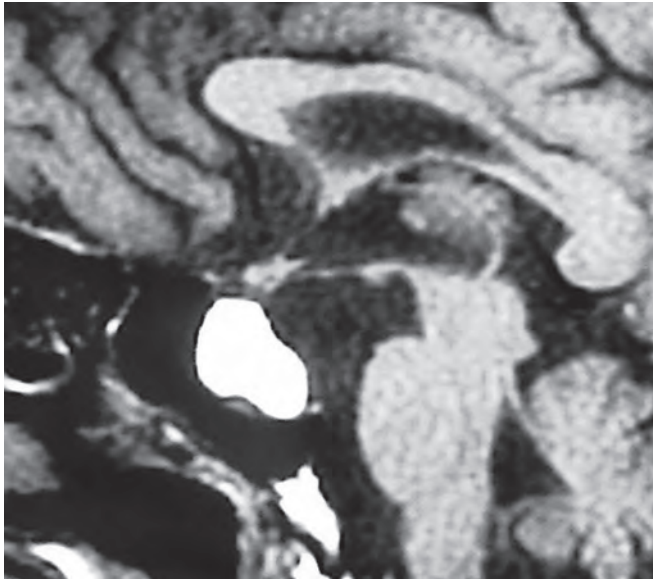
Sagittal T1-weighted contrast image showing the well defined uniformly hyperintense content of the Rathke's cleft cyst
